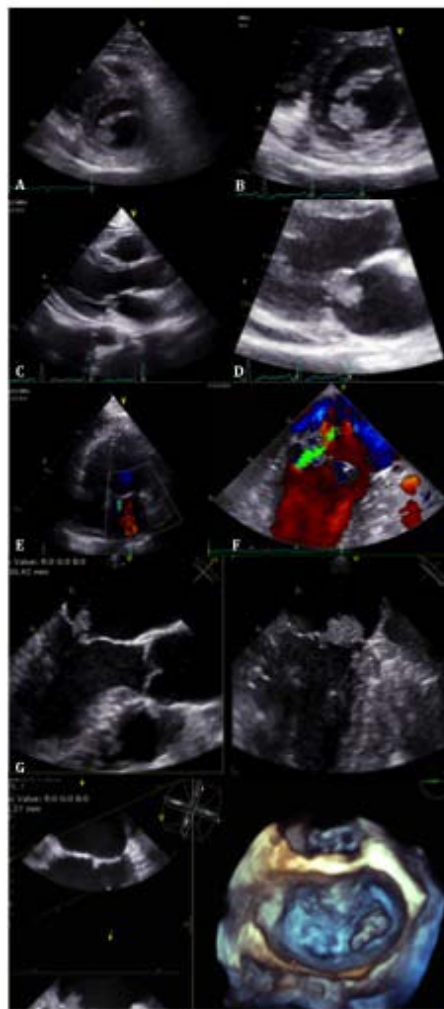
Echocardiographic study of the mitral mass: A, B - Transthoracic small axis view; C, D Transthoracic long axis view; E - Mild mitral regurgitation in transthoracic and (F) in transesophageal; G - transesophageal view.
